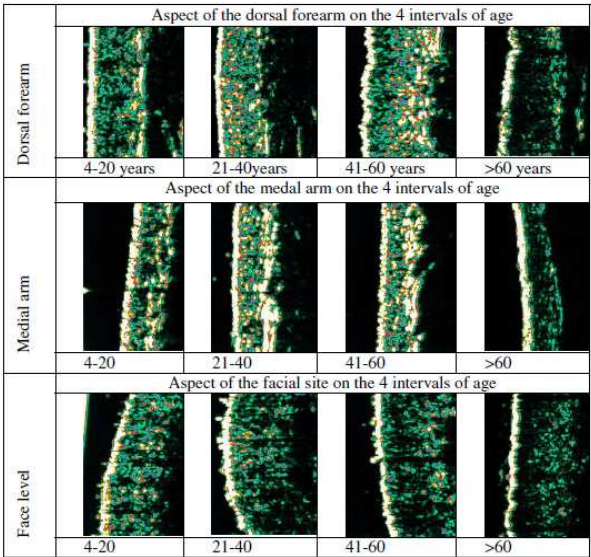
Ultrasonographic aspect of the dorsal arm, medial arm and facial site on the 4 studied age intervals
